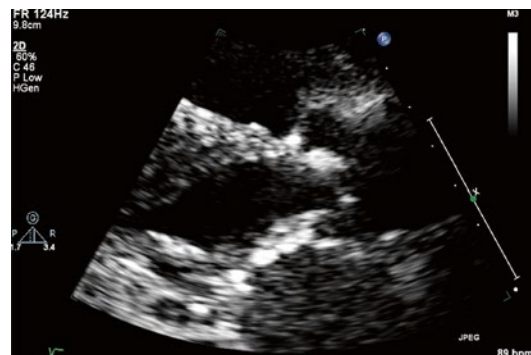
Parasternal long axis view of the left ventricle (LV), left ventricular outflow tract (LVOT) and aortic valve (AV). The aortic leaflets are thickened, appear moderately calcified and demonstrate decreased excursion during this mid-systolic frame
